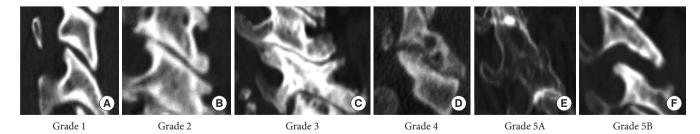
Newly developed computed tomography classification for cervical facet joint degeneration. (A) Grade 1, normal facet joint with no degenerative changes. (B) Grade 2, mild degenerative changes with only osteophyte formation. (C) Grade 3, degenerative changes with osteophyte formation including joint space narrowing, microcyst (<2 mm), or joint hypertrophy. (D) Grade 4, severe degenerative changes, including moderate to large cysts (≥2 mm), and articular irregularity. (E) Grade 5A, ankylosing changes with bony fusion of the facet joint. (F) Grade 5B, facet opening with articular irregularity.
